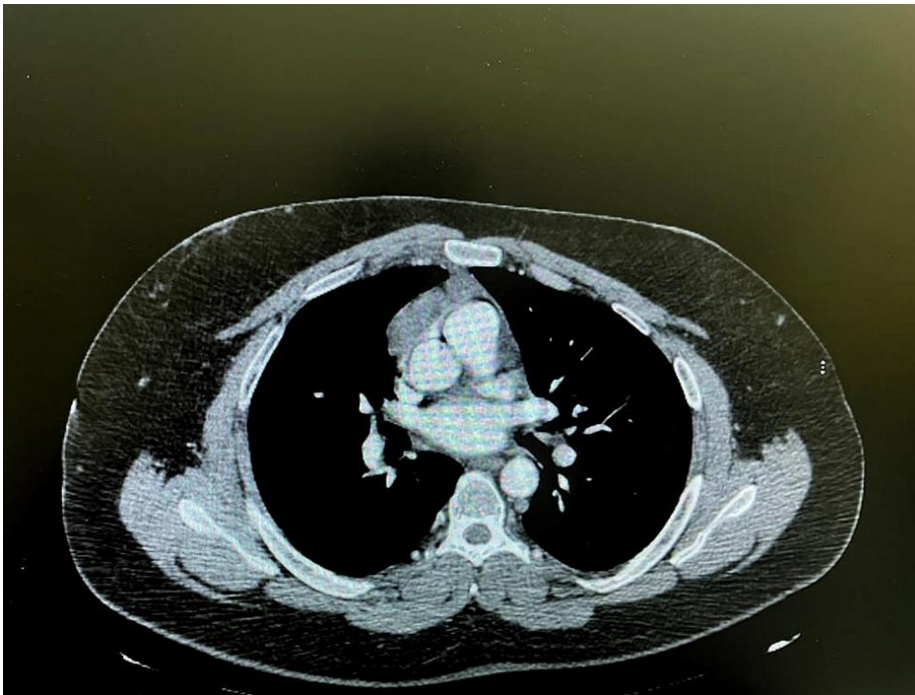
Chest CT repeated 7 months later showing almost 70% spontaneous regression of the anterior mediastinal mass.
